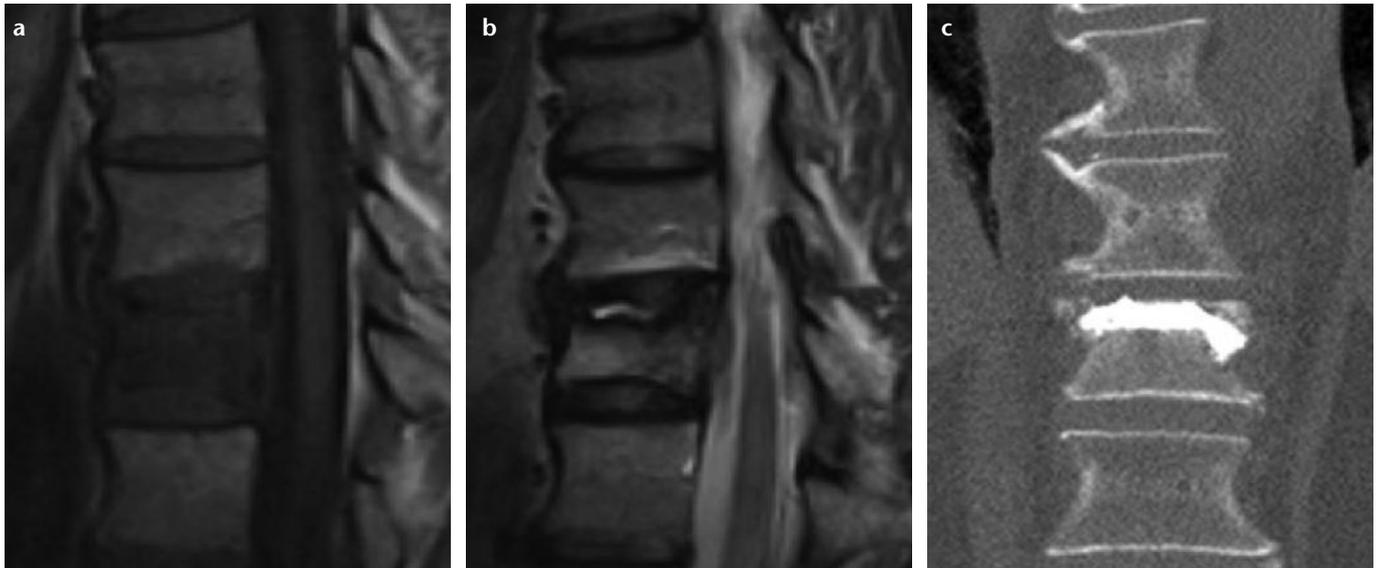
a–c. Combined CT/fluoroscopy guidance was used in this 65-year-old male with metastatic hepatocellular carcinoma involving the T10 vertebral body, given a posterior/lateral cortical defect and epidural spread of the tumor. Two selected T1 (a) and T2 (b) sagittal MR images demonstrate advanced T10 compression fracture. After completion of coblation and vertebroplasty, coronal CT image (c) confirmed the optimal intraosseous polymethylmethacrylate distribution.
